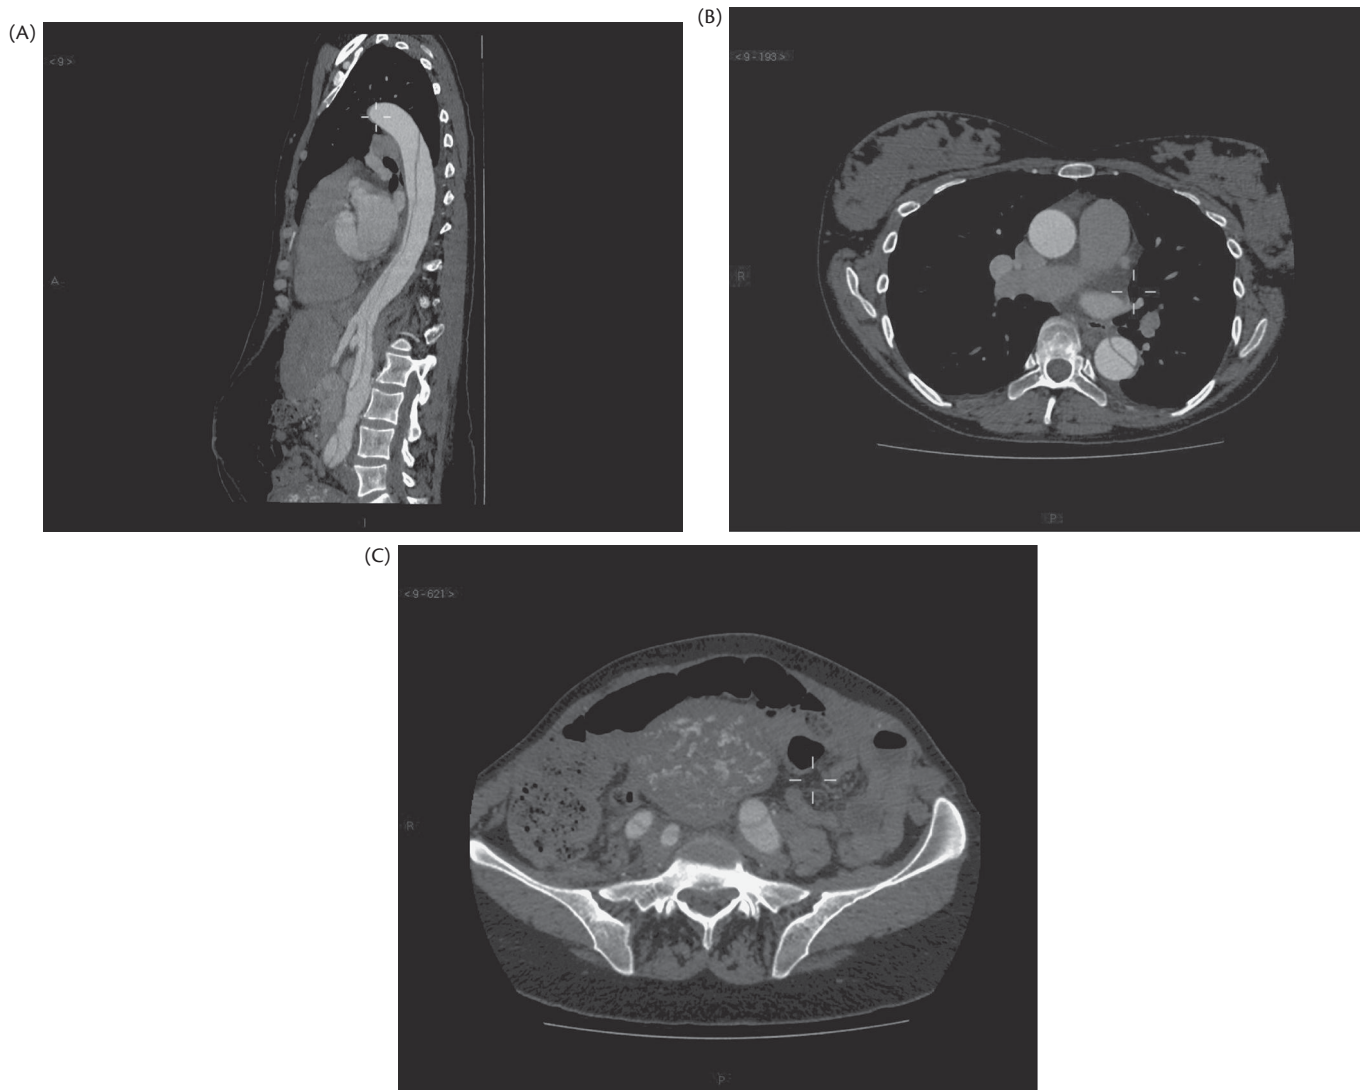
Computed tomography angiogram (CTA) of thoracic dissecting aneurysm. (A) Sagittal CTA showing dissection flap extending down from thoracic to abdominal aorta. (B) Axial image from CTA thorax. (C) Axial CTA image showing flap extending into both common iliac arteries with top of postpartum uterus. Thanks to Dr. Hamish Ireland for the CTA Images of the aortic dissection.
